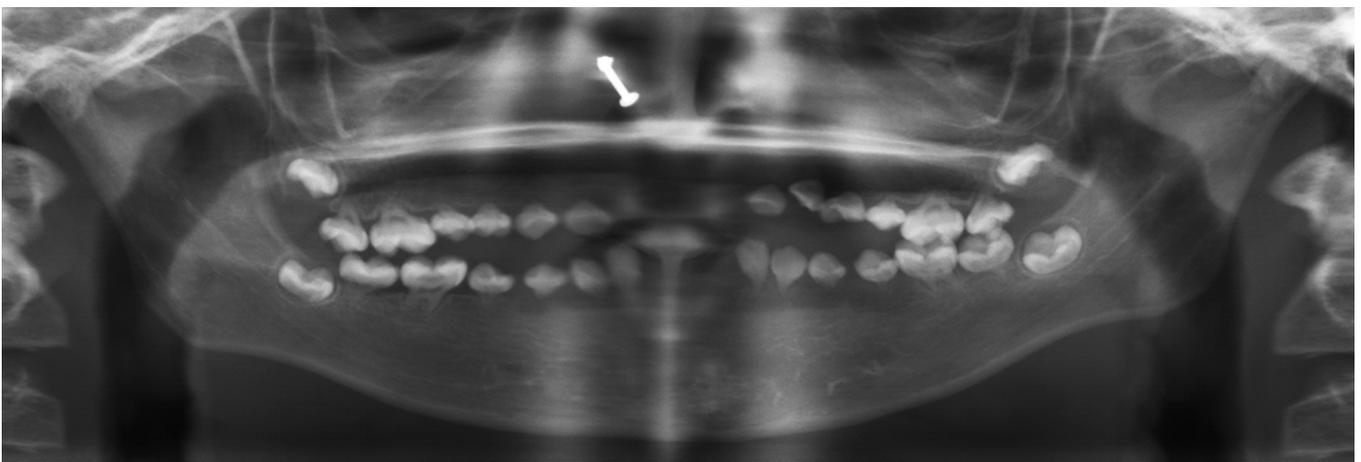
Panoramic radiography
